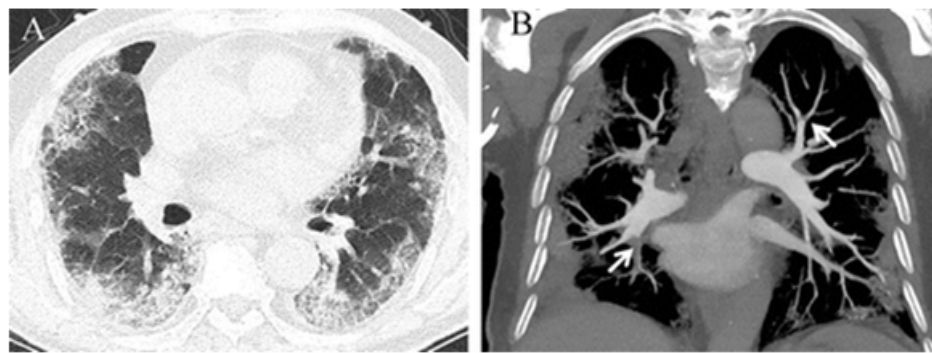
Patient of COVID-19 having Pneumonia with age 70 year.(A) On Day 2 CT Showing Ground Glass Opacities with Consolidation. (B) Angiography of Arteries at Lungs Showing Filling Defects [14].
